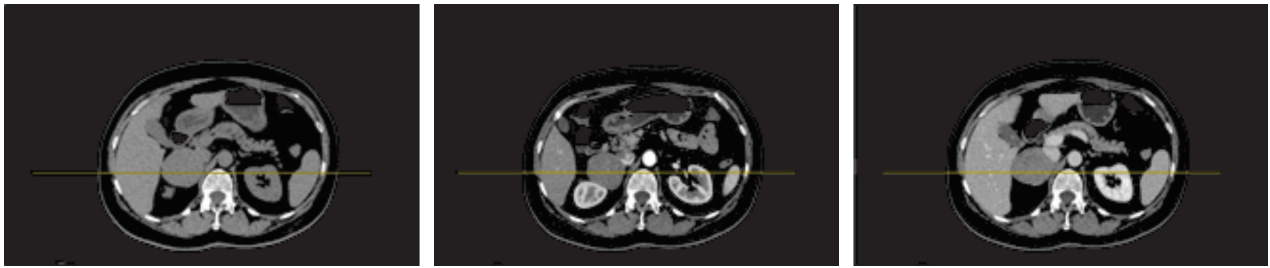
Mass in the retroperitoneal space on CT scans in axial views in the native, arterial, and venous phases (from left to right)
